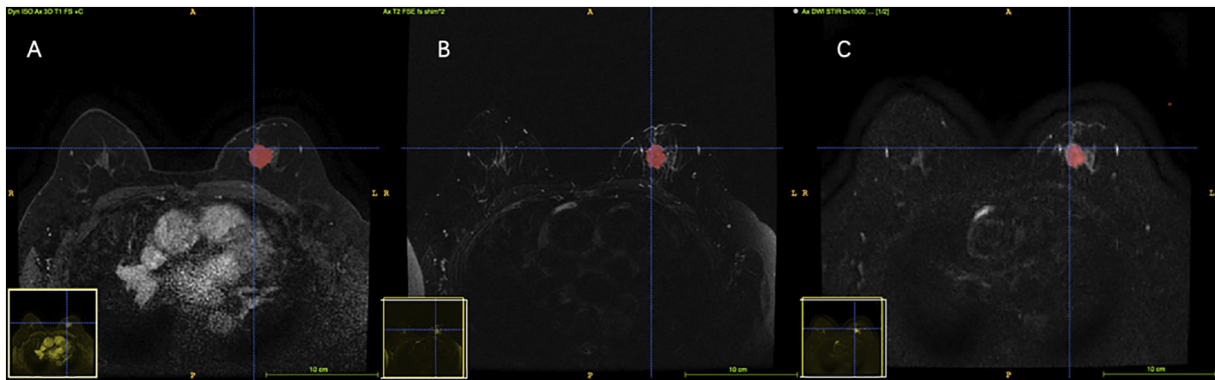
Tumor masking in different MR sequences. a. DCE b. T2WI c. DWI.
